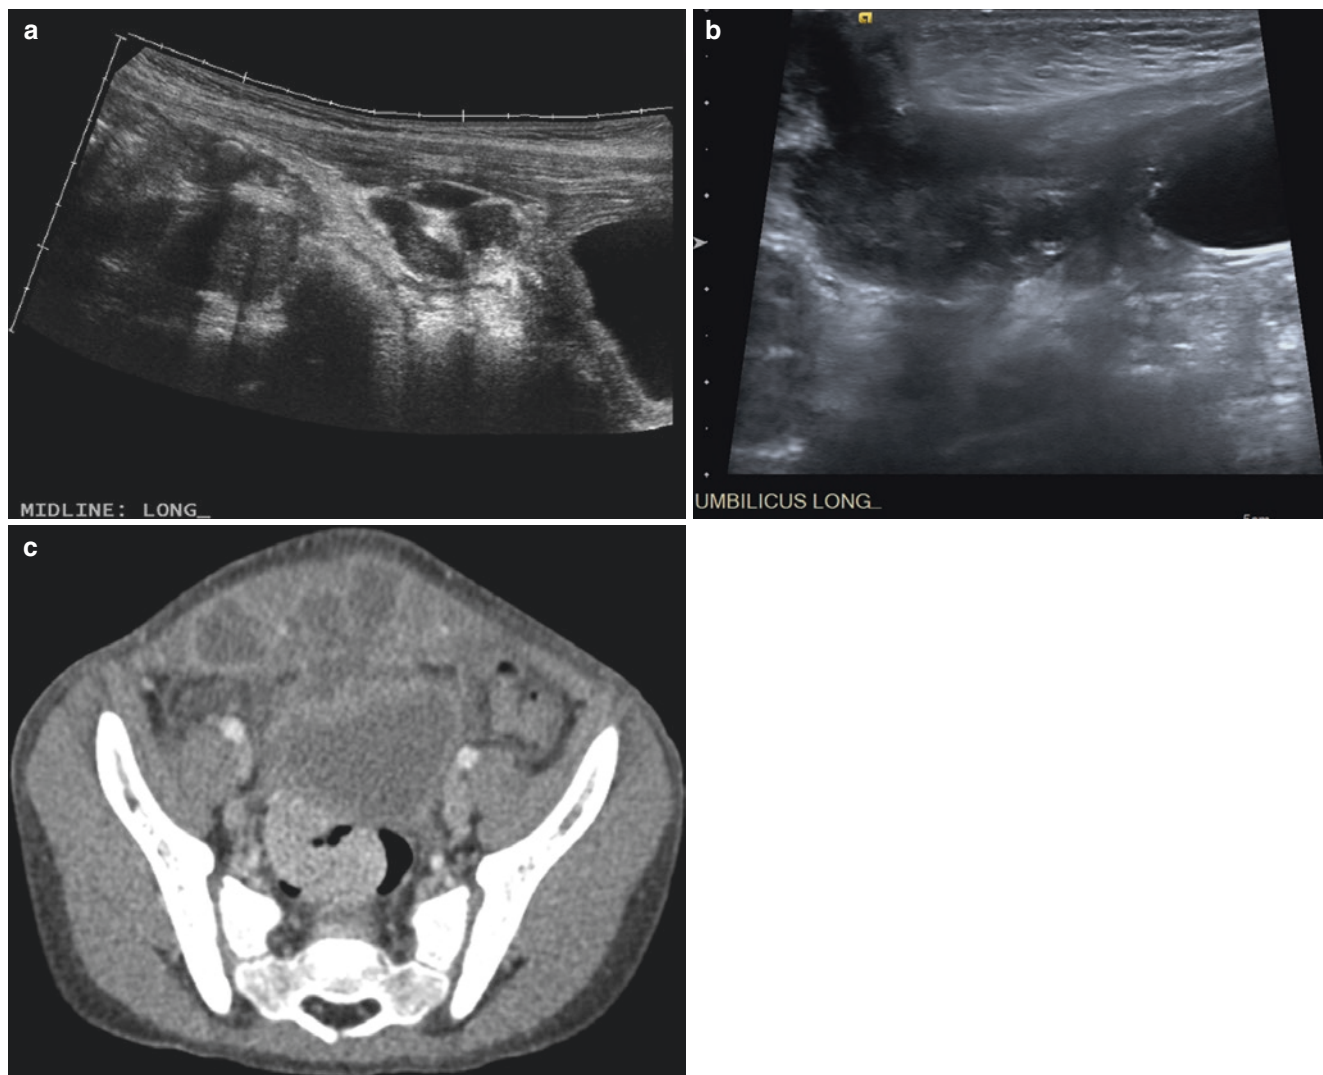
(a) Longitudinal ultrasound image of a urachal cyst. The bladder is on the right side of the image and contains anechoic urine. Superior to the bladder there is a complex cystic structure which is predominantly hypoechoic. (b) Longitudinal ultrasound image of an inflamed urachal cyst. Hypoechoic material can be seen extending from
